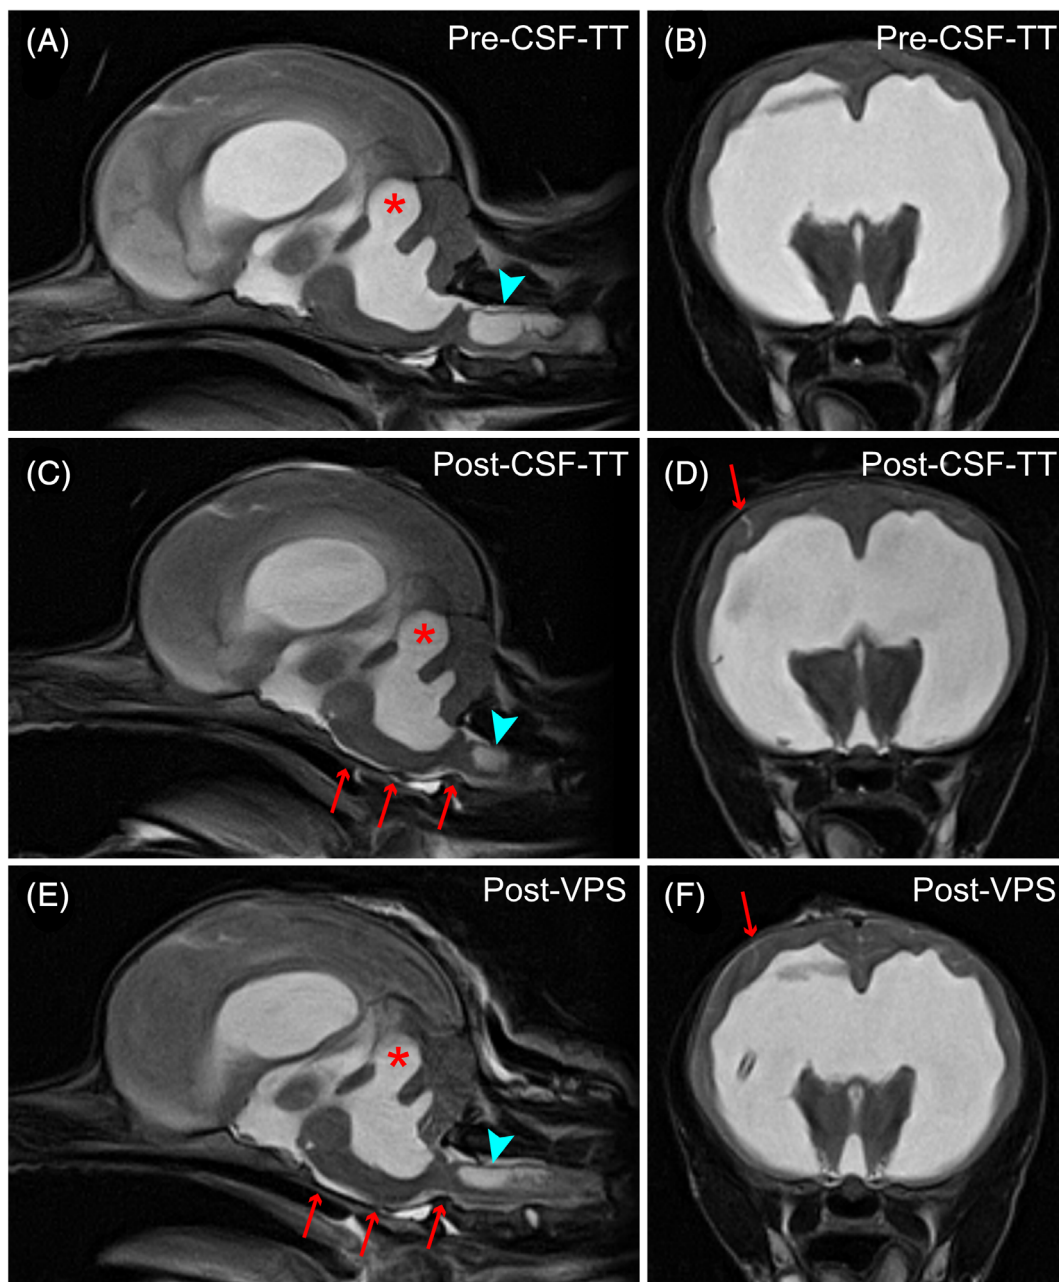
Sagittal and transverse T2-weighted (T2W) magnetic resonance (MR) images before the cerebrospinal fluid (CSF) tap test (TT), A,B, after CSF-TT, C,D, and after ventriculoperitoneal shunting (VPS), E,F. Before CSF-TT, the ventricles are extremely dilated with supracollicular fluid accumulation (asterisk) and cervical syringomyelia (blue arrow head). There was no CSF signal in the subarachnoid space surrounding the brain and spinal cord. After CSF-TT, CSF signal in the subarachnoid space was restored (red arrows). Post-VPS T2W images revealed visible reduction ventricular size, supracollicular fluid accumulation (asterisk) and syrinx (blue arrowhead), and reappearance of CSF signal in the subarachnoid space (red arrows)
